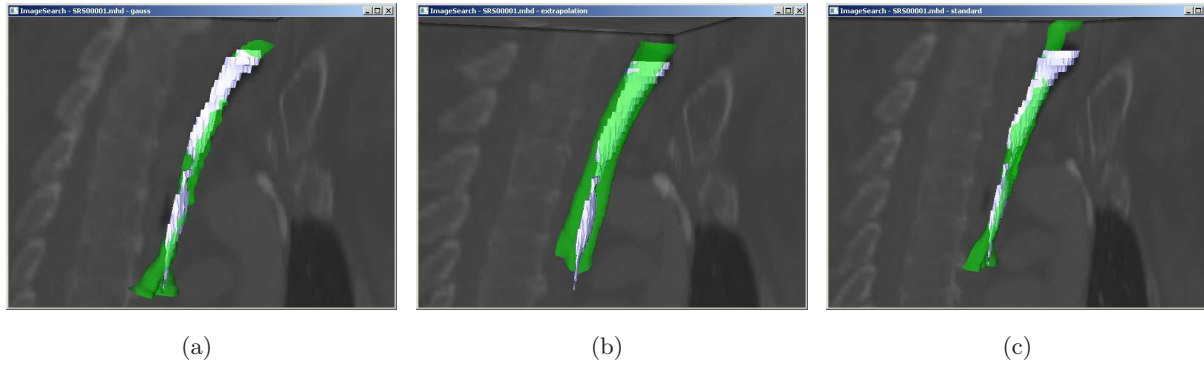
Gauss WLS* (a), *Surface Extrapolation* (b), and *StandardLS* (c) registration methods applied to the CT scan of Patient 1. The estimated trachea, in green, is placed in the image, overlaid on the segmented stenotic trachea. With *Surface Extrapolation*, the estimated surface failed to match the lower part of the trachea. With other methods, the surface was too narrow or deformed (compare with Figure 6.9(a)).
